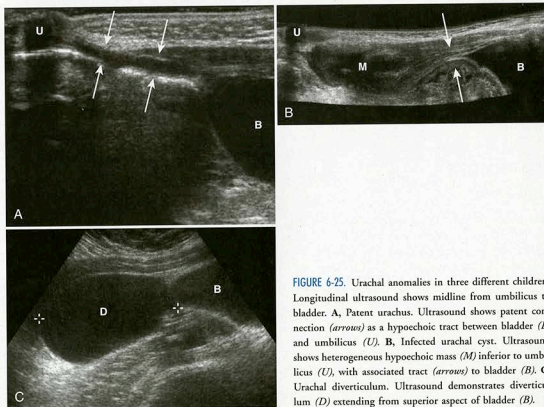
Urachal anomalies in three different children. Longitudinal ultrasound shows midline from umbilicus to bladder. A, Patent urachus. Ultrasound shows patent connection (arrows) as a hypoechoic tract between bladder (B) and umbilicus (U). B, Infected urachal cyst. Ultrasound shows heterogeneous hypoechoic mass (M) inferior to umbilicus (U), with associated tract (arrows) to bladder (B). C, Urachal diverticulum. Ultrasound demonstrates diverticulum (D) extending from superior aspect of bladder (B).
